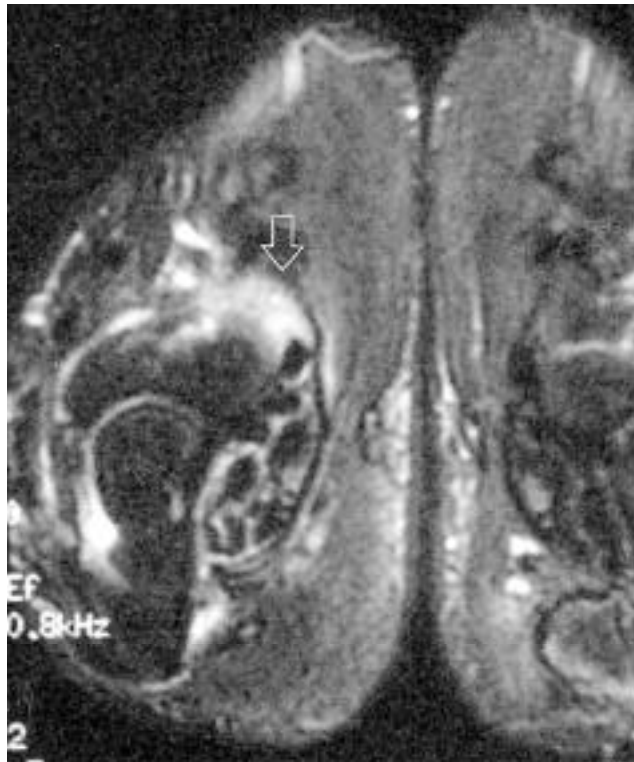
Axial T1-weighted image through the wrists showing fluid in the right radial bursa (arrow).
